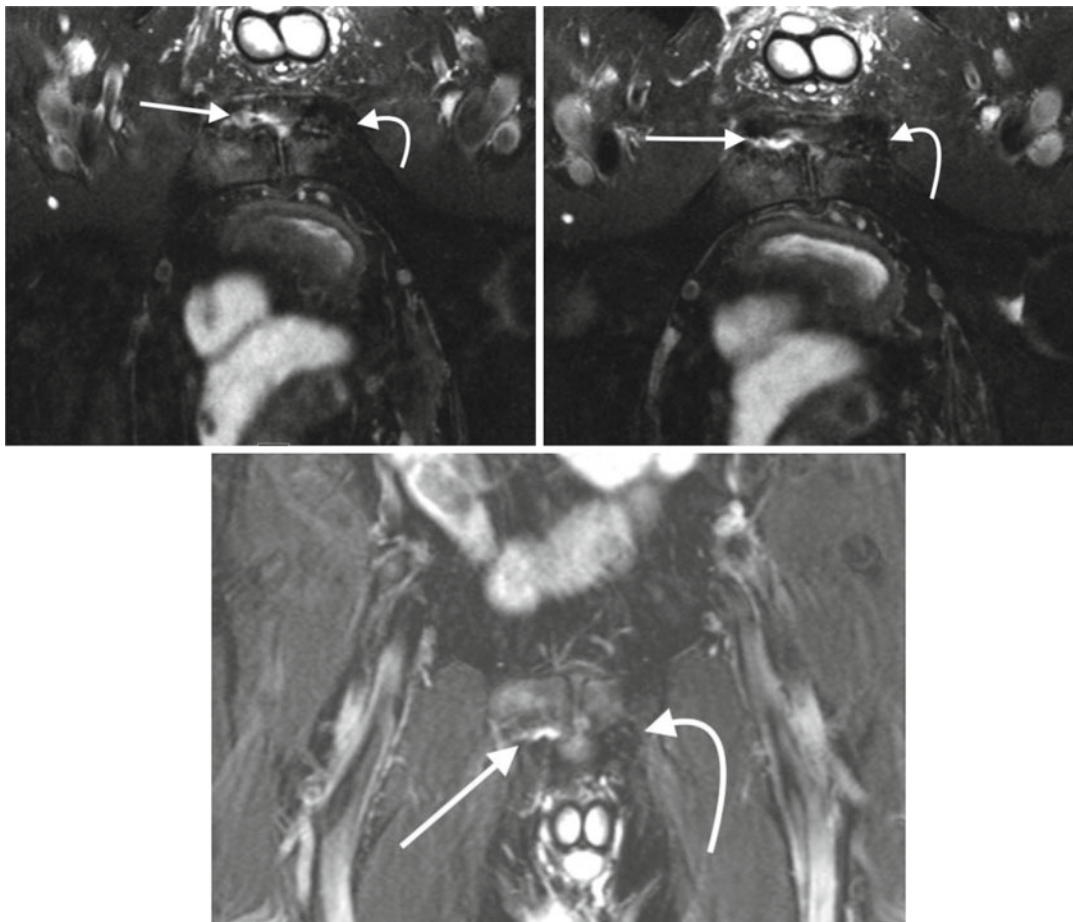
(Top left, top right) Axial and (bottom middle) coronal T2-weighted fast spin echo fat-saturated MR images show disruption with hematoma/granulation tissue (white arrows) at the right rectus abdominis-adductor
